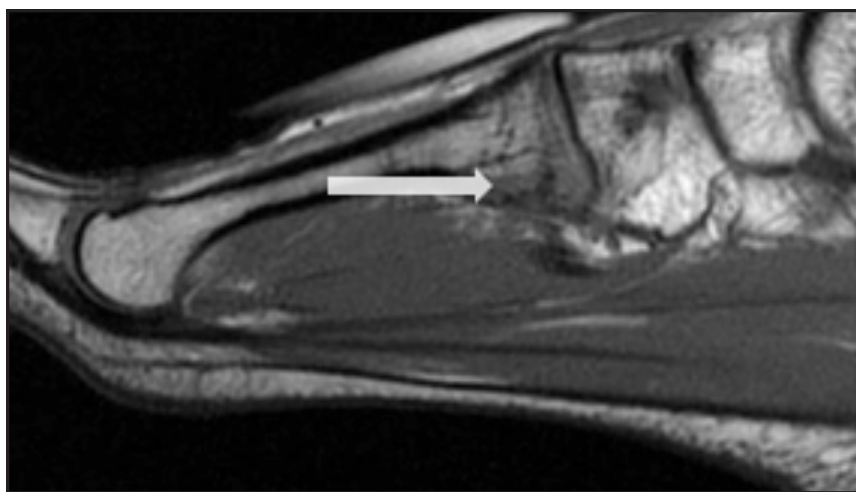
T1-weighted sagittal MRI of right foot with minimally displaced fracture at base of the 2nd metatarsal (arrow).
